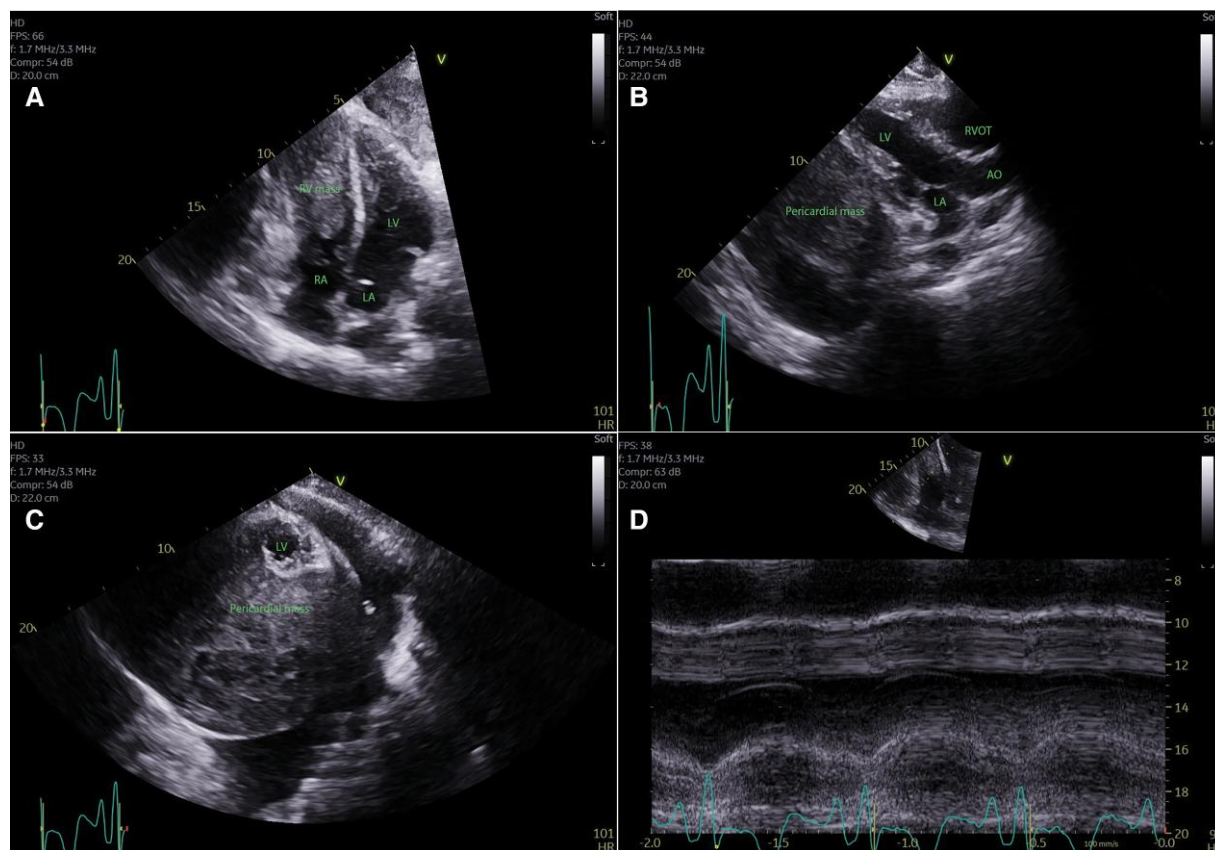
(A) Baseline apical four-chamber view on transthoracic echocardiogram. LA, left atrium; LV, left ventricle; RA, right atrium; RV mass, right ventricle with intracavitary mass. (B) Baseline parasternal long-axis view on transthoracic echocardiogram. LA, left atrium; LV, left ventricle; RVOT, right ventricular out-flow tract; AO, aorta. (C) Baseline parasternal short-axis view on transthoracic echocardiogram. LV, left ventricle. (D) Baseline tricuspid annular plane systolic excursion measurement of 12 mm.
